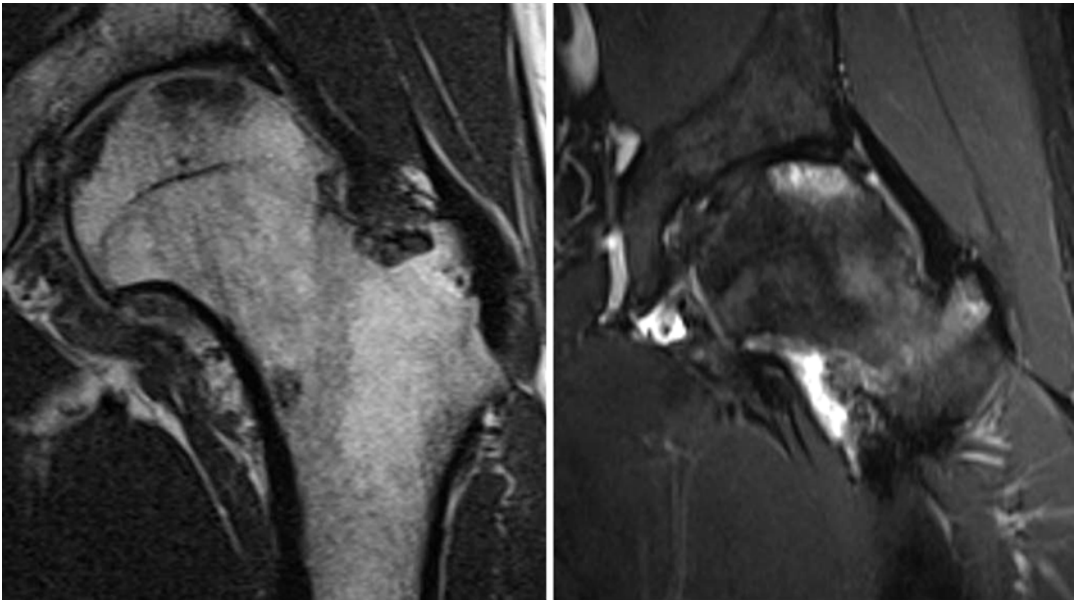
T1- and T2-weighted MRI with gadolinium of the same patient showing “Large osteochondral lesions and labral tear
